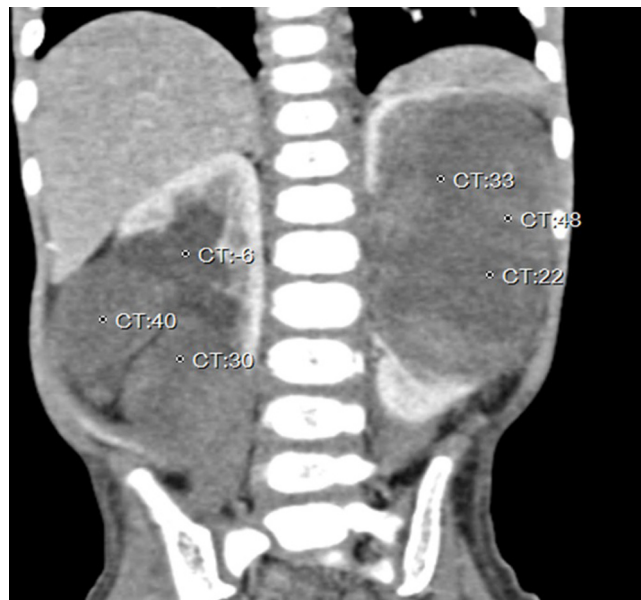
Coronal image of venous phase of CT scan shows heterogeneous contrast enhancement of mass lesions.
